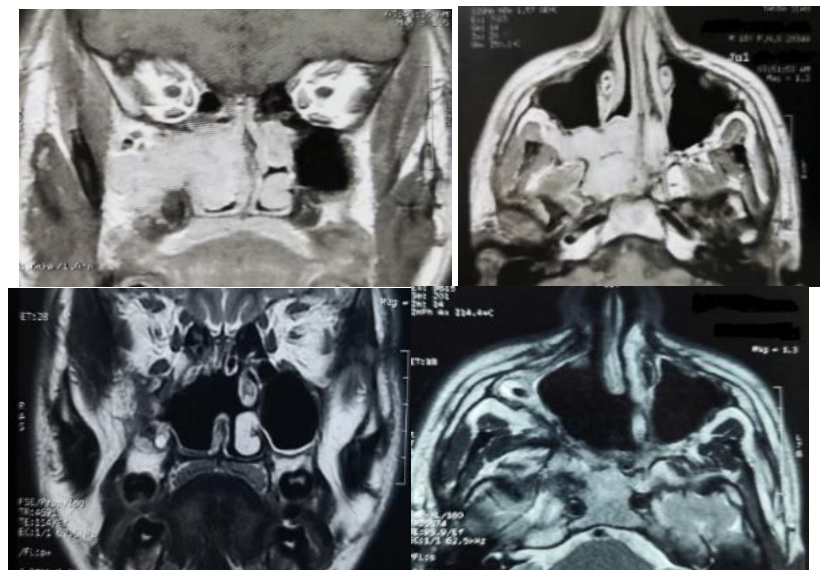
MRI of case with JNA: pre-operative imaging shows the tumor involving right side of nasal cavity, PPF, ITF, sphenoid sinus closing to ICA (stage IV b). Post-operative imaging shows no recurrence with EETA with posterior septectomy to aid in removal of the lesion.
